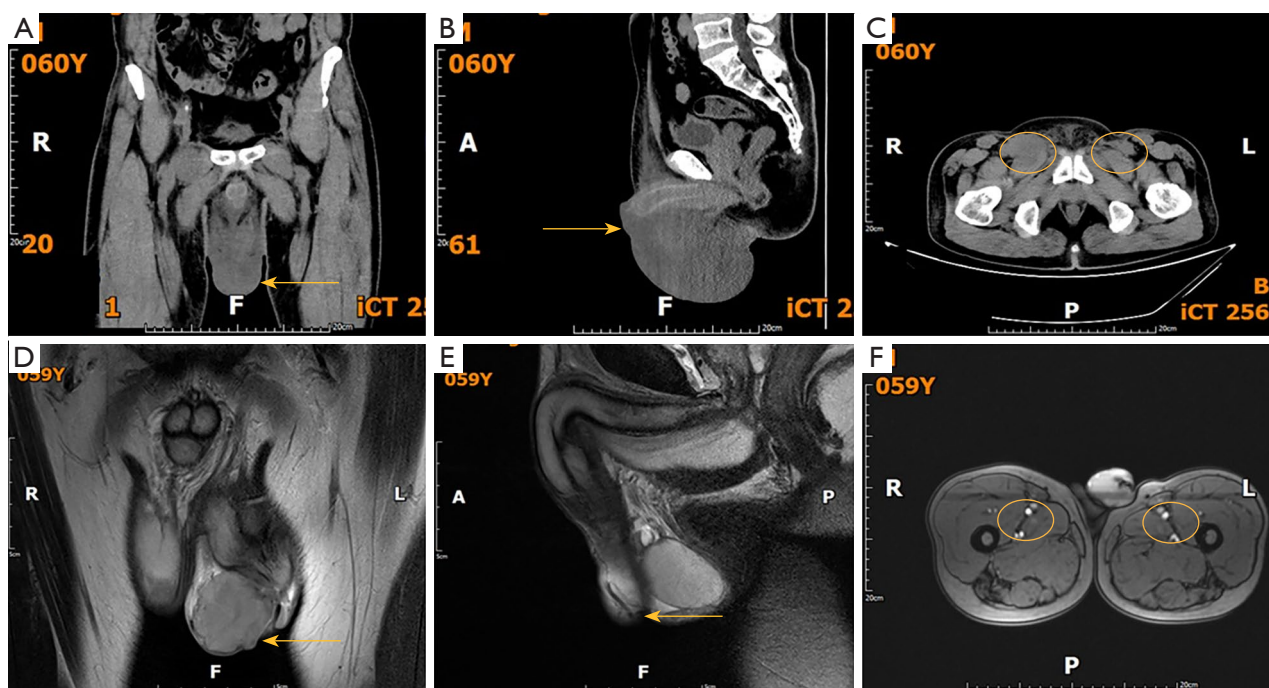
CT scan results. Tomographic CT images (A-C) of the lower abdomen and pelvis and MRI images (D-F) show: (A) coronal CT image of the abdomen of a 60-year-old patient. The arrow indicates an irregular space-occupying lesion; (B) sagittal CT image of the abdomen of a 60-year-old patient. The arrow points to an irregular space-occupying lesion; (C) axial CT image of the abdomen of a 60-year-old patient. The area marked by the yellow circle is an irregular space-occupying lesion; (D) coronal MRI image of the pelvis of a 69-year-old patient. The arrow indicates an irregular space-occupying lesion; (E) sagittal MRI image of the pelvis of a 69-year-old patient. The arrow points to an irregular space-occupying lesion; (F) axial MRI image of the pelvis of a 69-year-old patient. The area marked by the yellow circle is an irregular space-occupying lesion. There is an irregular space-occupying lesion in the coronal and sagittal positions of the head of the penis, measuring approximately 3 cm × 2 cm × 2 cm, without involvement of the surrounding organs of the penis such as the testes and the bladder. The axial images of CT and MRI show enlarged inguinal lymph nodes (marked by circles in C and F), and their exact nature needs to be confirmed by pathological examination. CT, computed tomography; MRI, magnetic resonance imaging.
